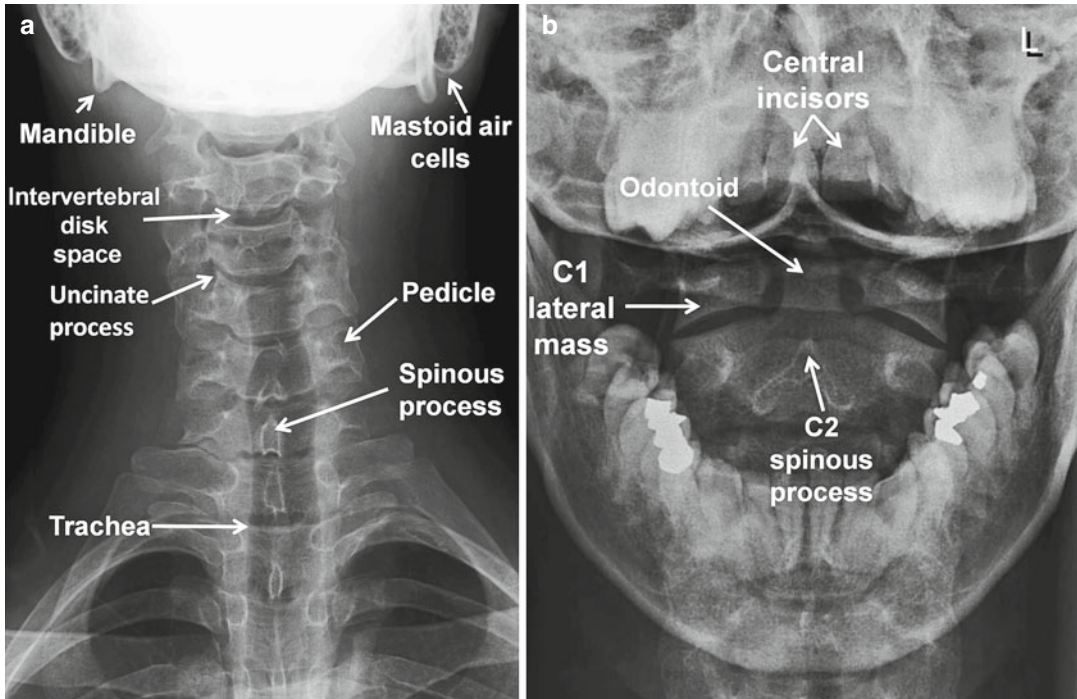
Normal radiographic anatomy on AP cervical spine (a) and open-mouth odontoid (b) radiographs with labeled pertinent anatomy
